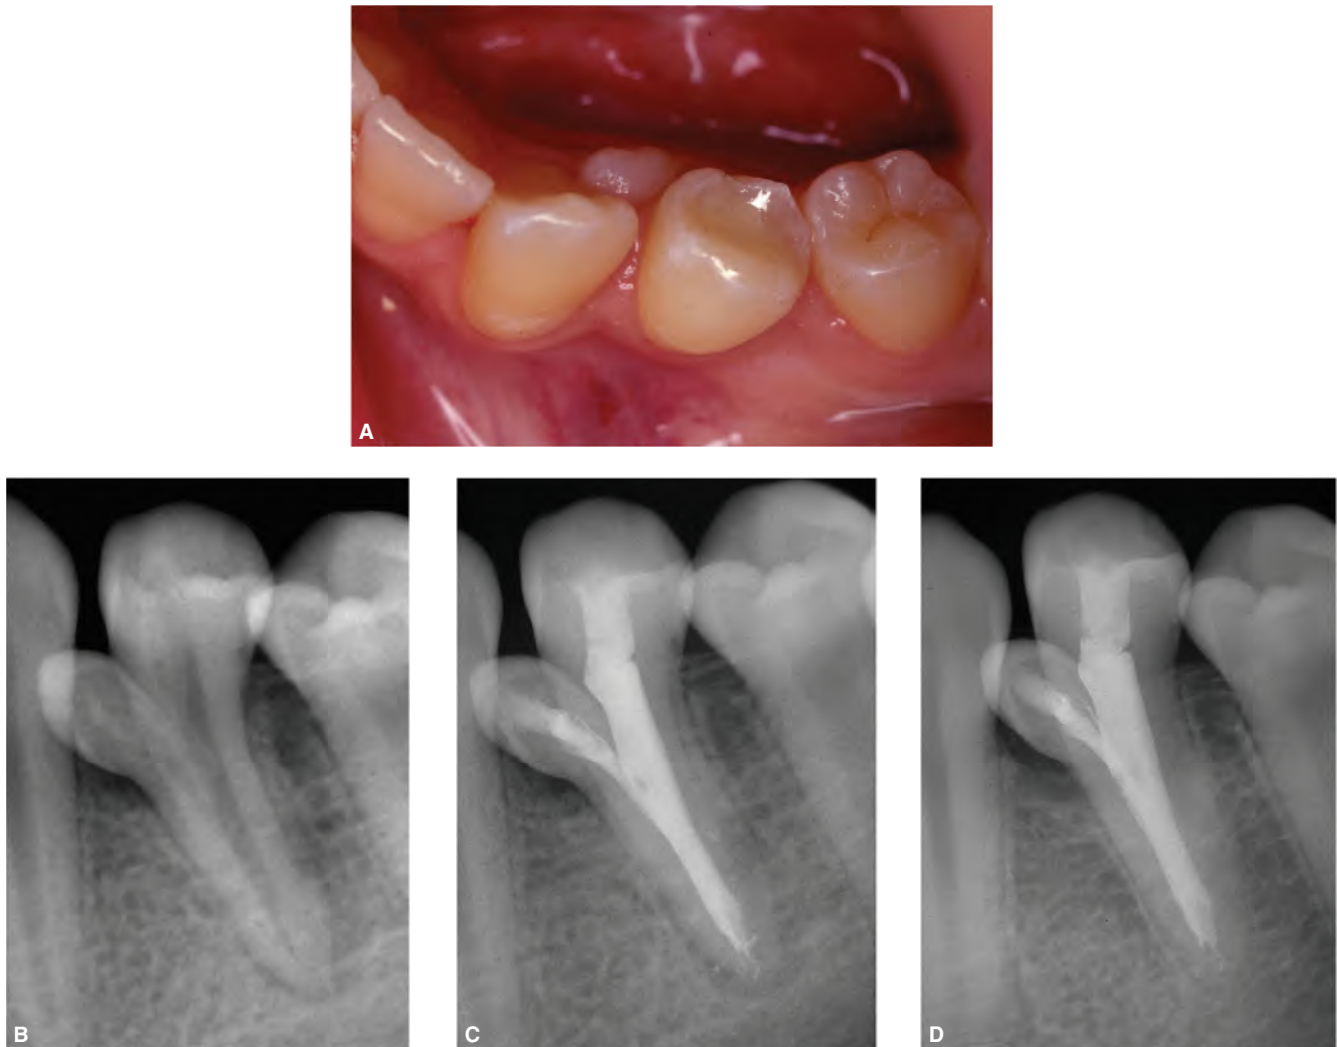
Fusion of a mandibular first premolar with a supernumerary tooth in a 15-year-old male. A. Clinical view. The crown of the supernumerary tooth is located mesio-lingually to the premolar. B. Preoperative radiograph showing the fused teeth with a joint root canal system. Periapical radiolucency is evident. Pulp vitality tests were negative. C. Immediate post operative radiograph. D. Four-year follow-up radiograph showing resolution of the periapical radiolucency. (Courtesy of Dr. Fernando Goldberg, Buenos Aires, Argentina.)
